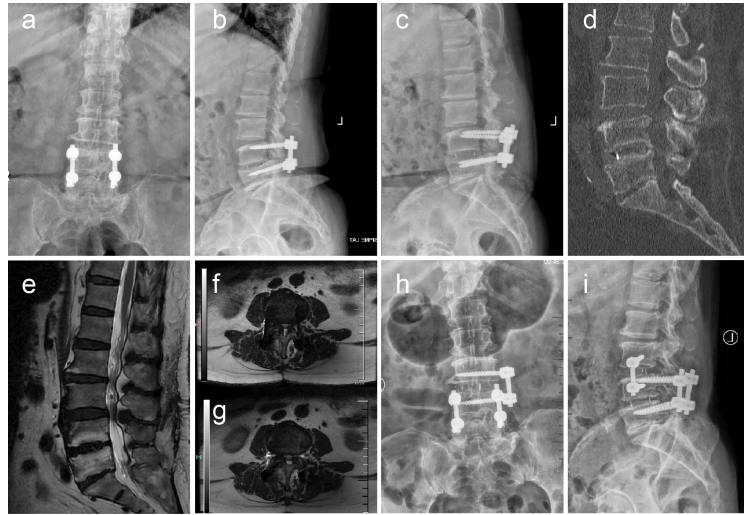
Images obtained from a 78-year-old woman who had L4-5 transforaminal lumbar interbody fusion surgery 6 years ago. She complained of lower back and bilateral leg pain for 6 months, while the pain could be relieved during rest. The lumbar spinal AP (anterior-posterior), lateral view (a, b) and over-extension view (c) have shown segmental instability at L3-4 after L4-5 TLIF; Lumbar spinal sagittal CT reconstruction view (d) has shown no evident calcification at the L3-4 intervertebral disc; Preoperative Lumbar spinal MRI images (e, g, f) have shown lumbar stenosis at L3-4 level; The patient has undergone L3-4 OLIF augmented with lateral vertebral screws and postoperative lumbar spinal AP and lateral view (h, i) have shown satisfied realignment of lumbar spine. The patient's lower back and bilateral leg pain improved immediately after revision surgery.
